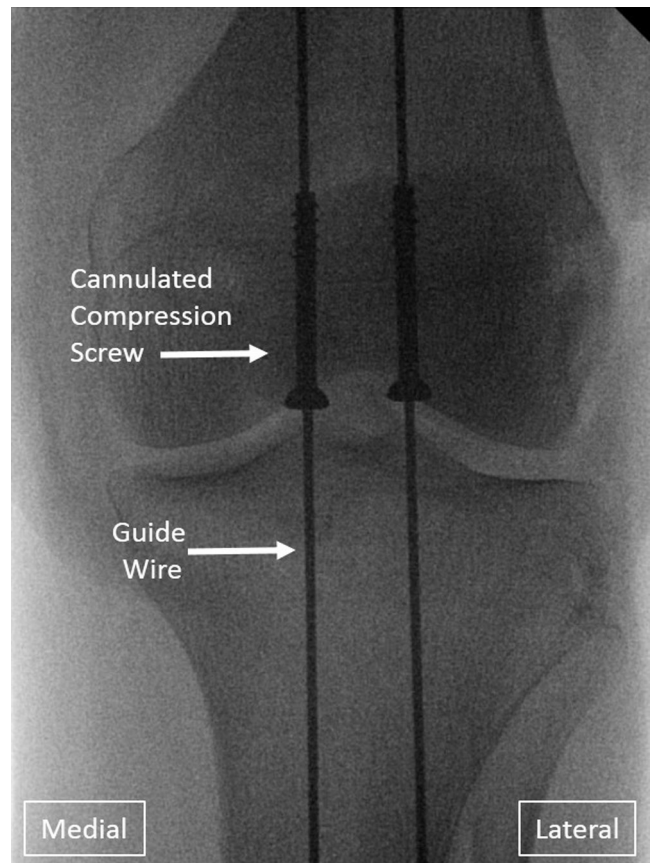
Patella fracture fixation in left knee, intraoperative anteroposterior radiograph. Two 4.0-mm partially threaded, blunt tip cannulated screws are placed over the guidewires. The screw heads are buried into the distal cortex, and the blunt screw tips are left short of the proximal cortex.
